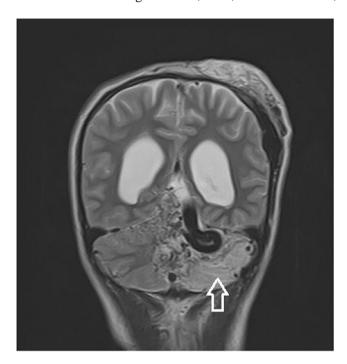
MRI brain coronal T2-weighted demonstrates hyperintense area in the left cerebellar hemisphere (white arrow) suggesting an acute infarction.
